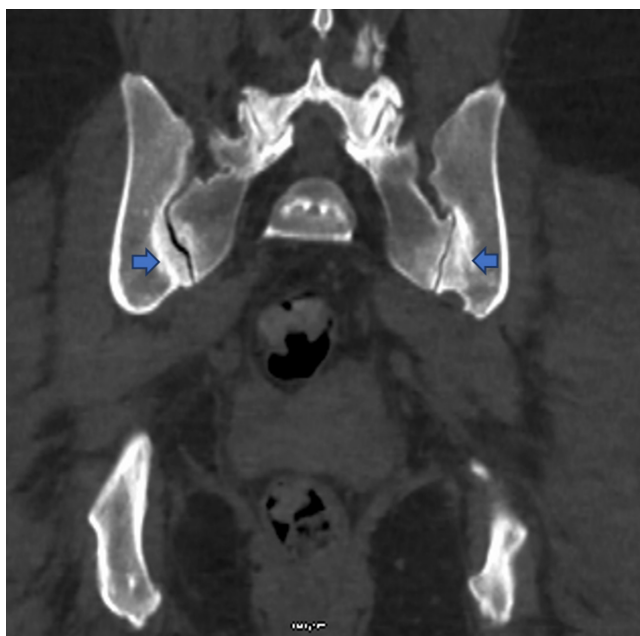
Coronal CT scan showing similar sclerosis of iliac bones (arrow) adjacent to sacroiliac joints typical of Osteitis Condensans Illii.
